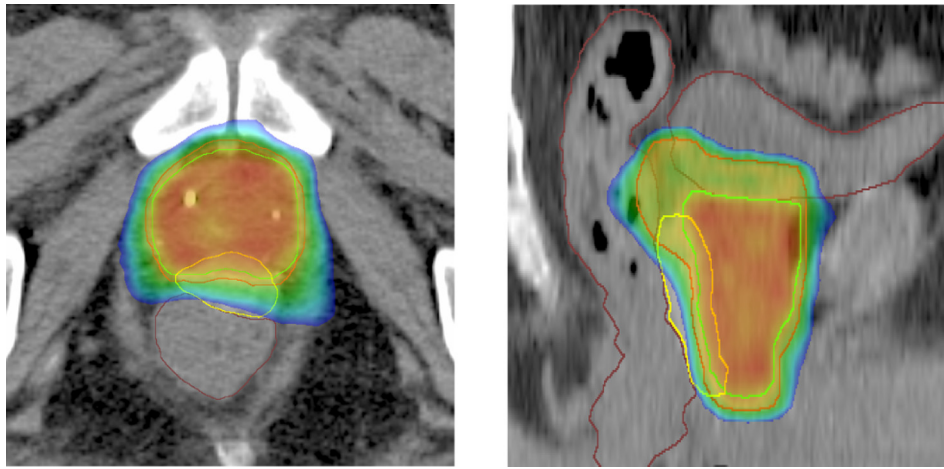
Color-wash isodose distribution in an axial (a) and sagittal (b) CT plane after RBI (yellow) implantation, with prostate PTV1 (green), PTV2 (red). The prescribed dose to PTV1 and PTV2 was 65.8 and 70 Gy, in 28 fractions of 2.35 and 2.5 Gy, respectively. Image (a) shows the high-dose region >70% (blue) with nearly no overlap in the rectum (brown). The high-dose region >85% (green) reveals no overlap at all within the rectum. In image (b) at the more cranial part there is minimal overlap observed. *Abbreviation:* RBI = Rectal Balloon Implant; PTV = Planning Target Volume.
